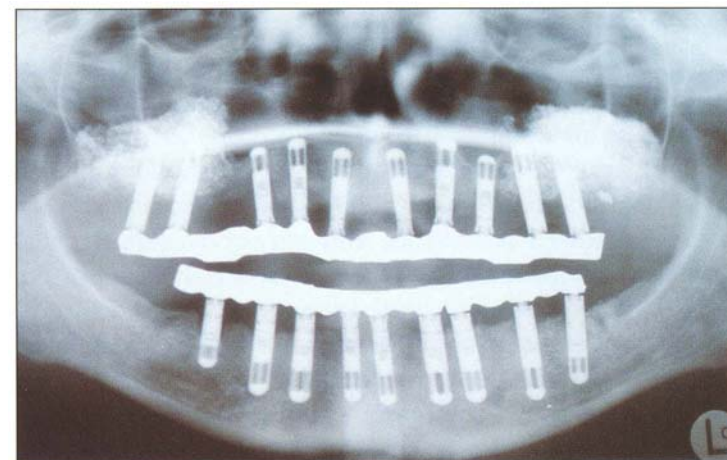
Panoramic radiograph of the implant-supported restorations 3 years postoperatively.
